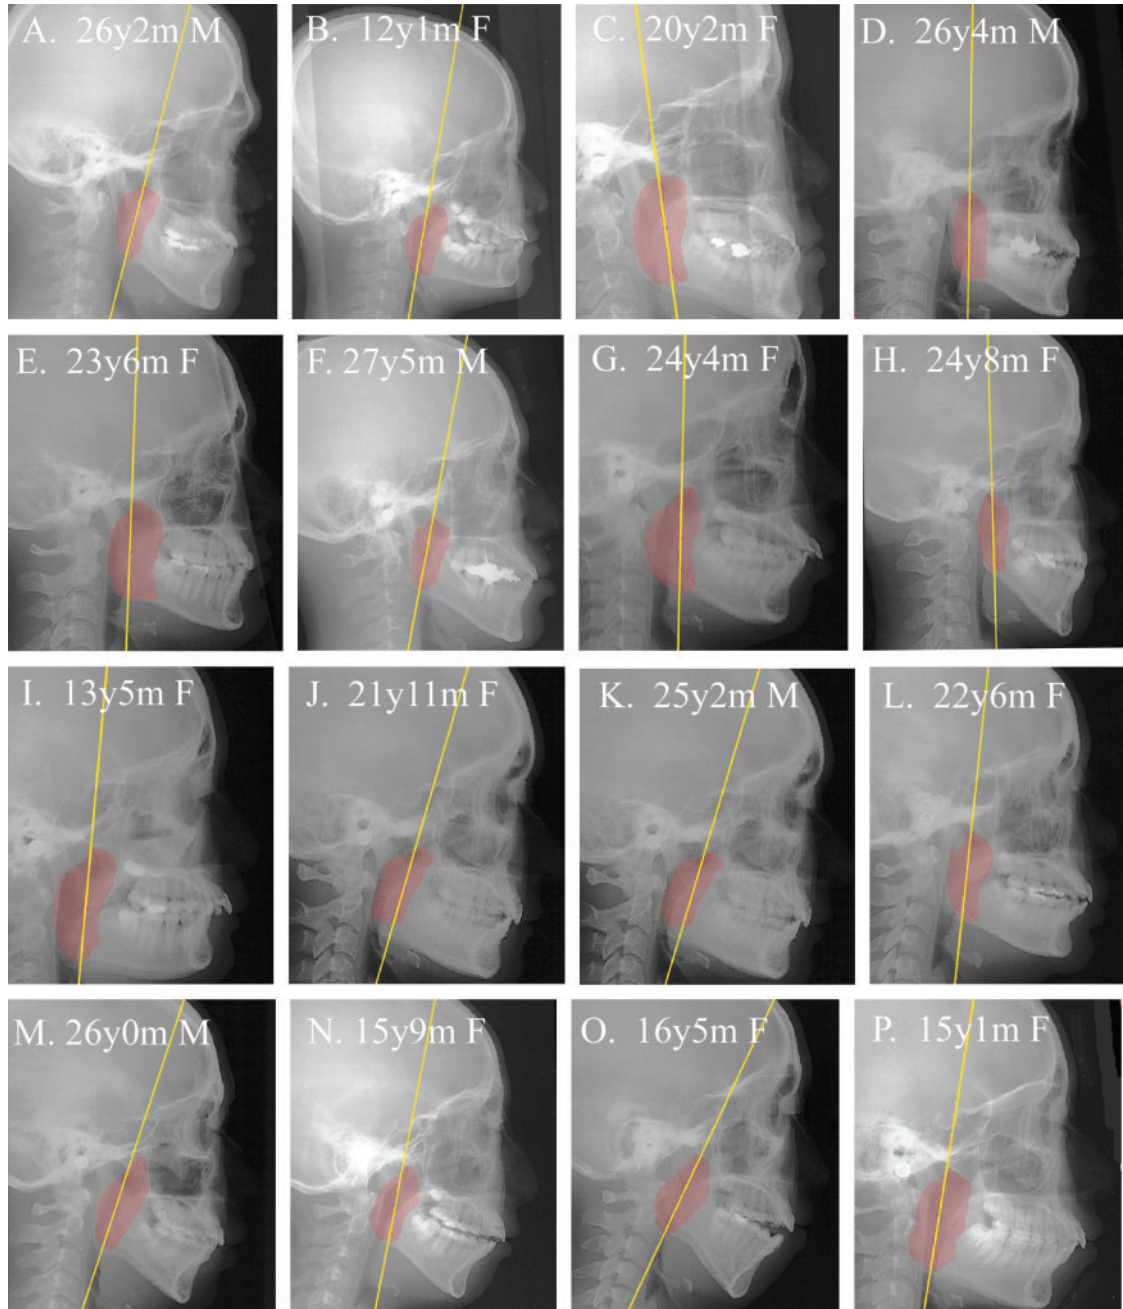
Superimposition of MRI and cephalogram images of 16 subjects
